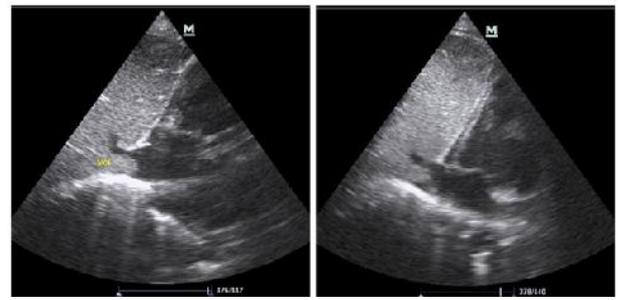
Transthoracic echocardiography. Solid and non-vascularized imagen in the lumen of inferior cava vein.
